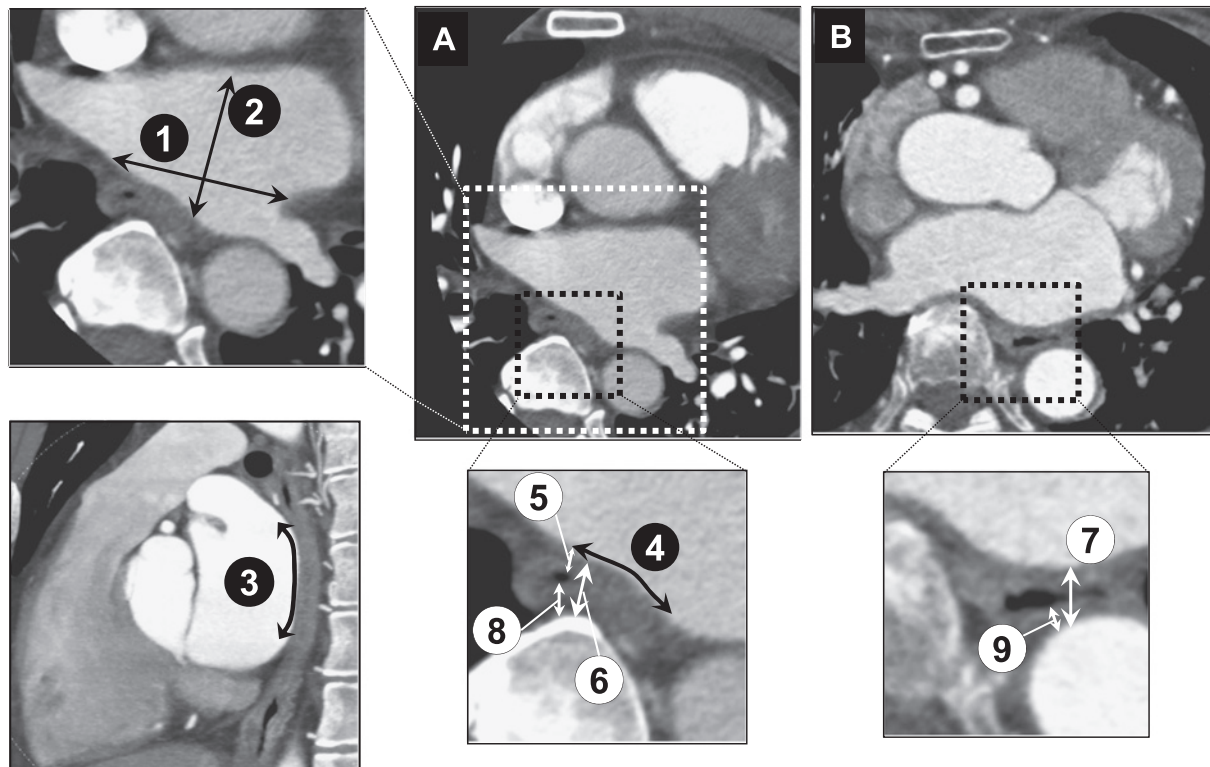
The anatomical variables measured in computed tomographic images.
